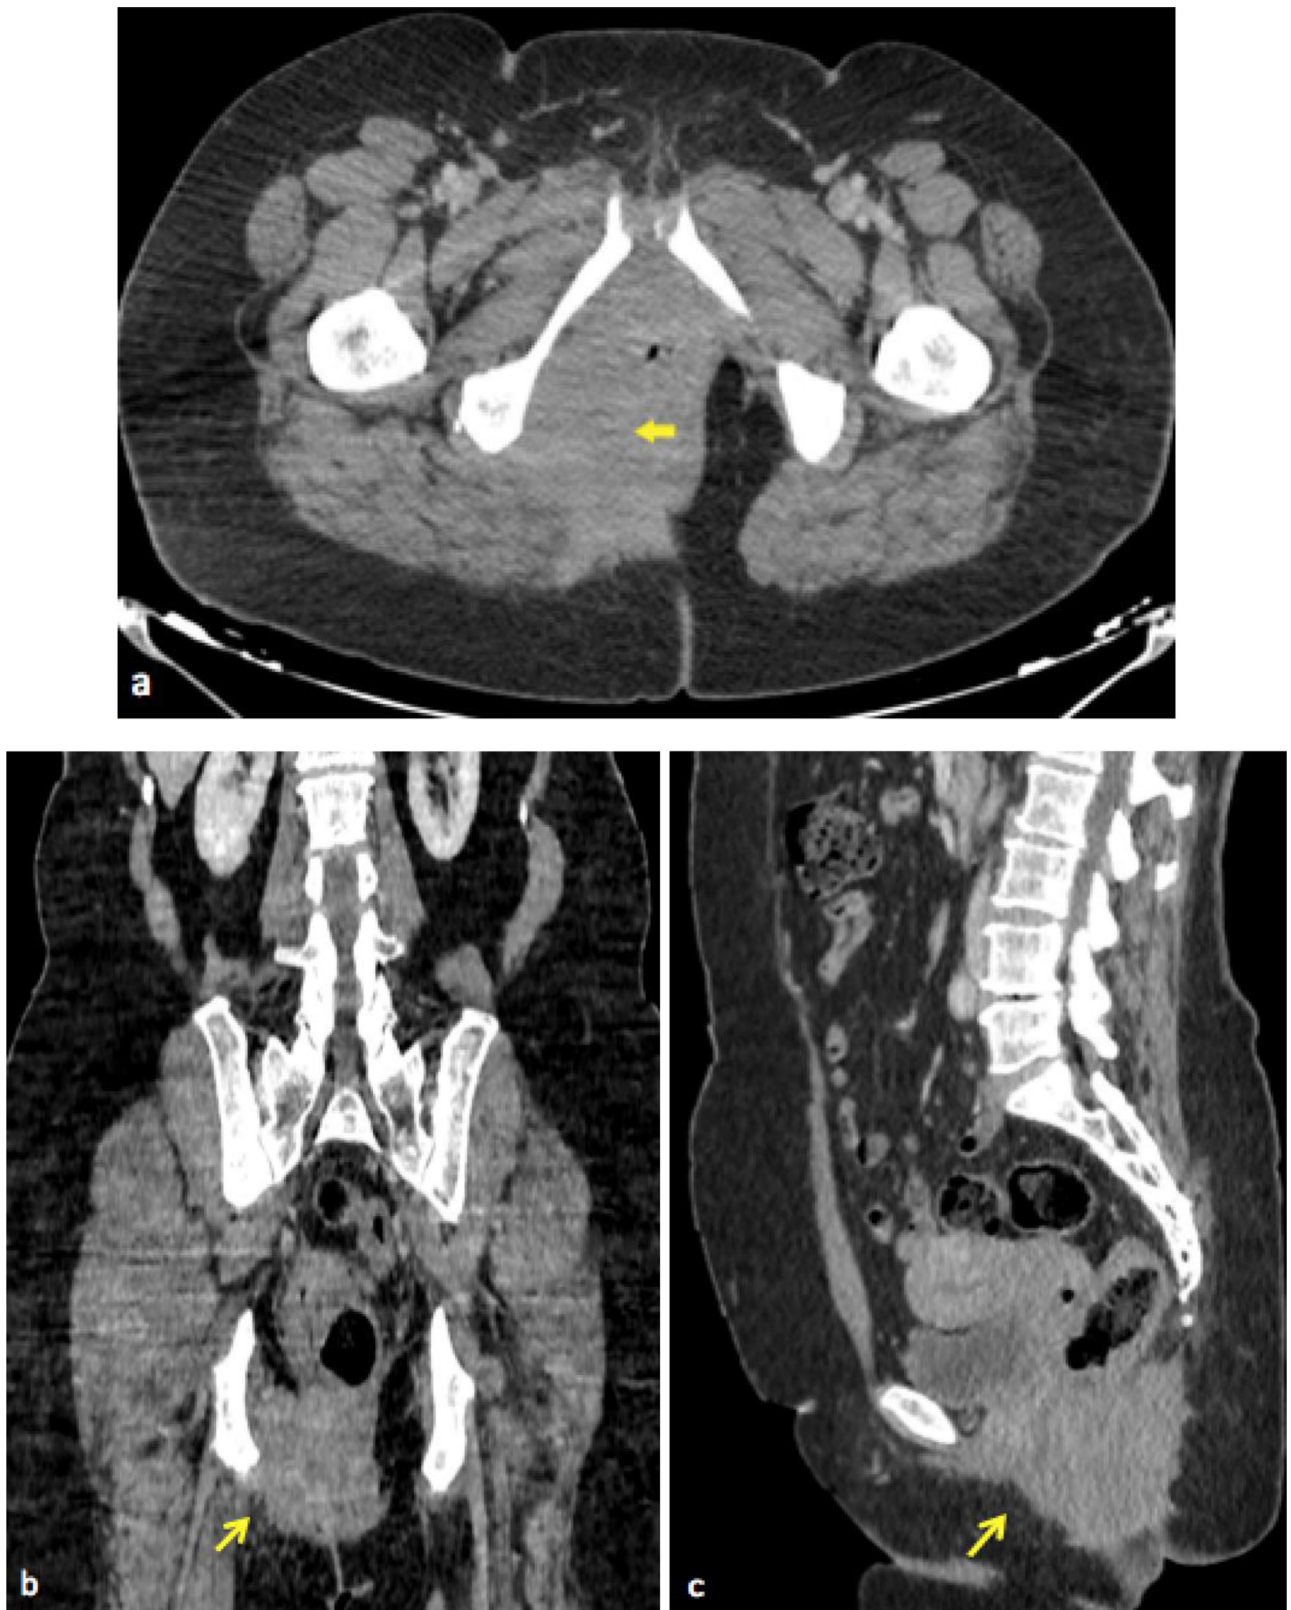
Axial (A), coronal (B) and sagittal (C) CT scan showing a mass occupying the right para-anal region.
